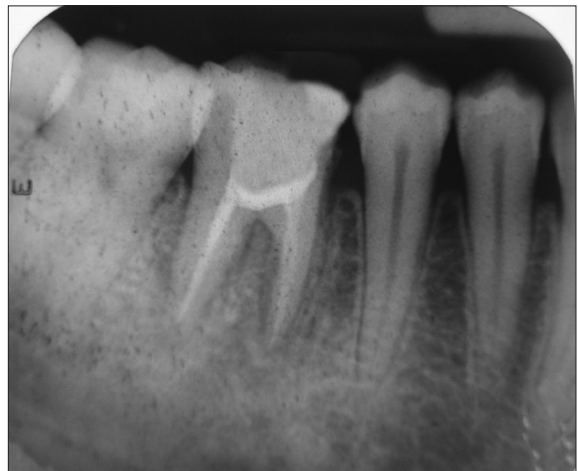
Post-operative IOPA X-ray
